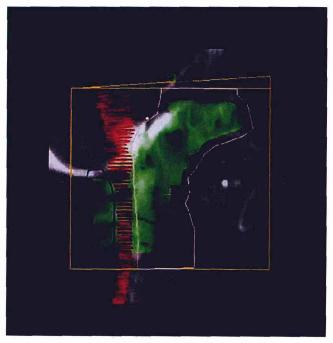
Digitally reconstructed radiograph of a lateral head and neck field showing the planning treatment volume (green), spinal cord and brainstem (red). The field apertures are shown (pink and blue) as well as the direction of the wedge.
